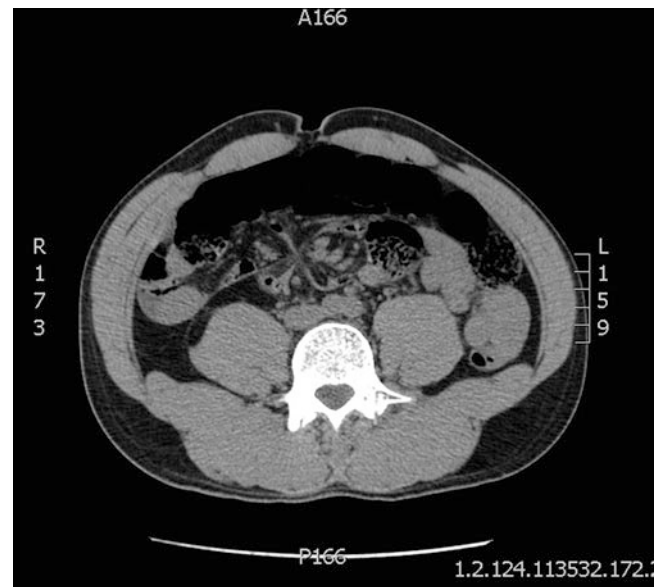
CT demonstrating mesenteric twisting found in patient with cecal volvulus
